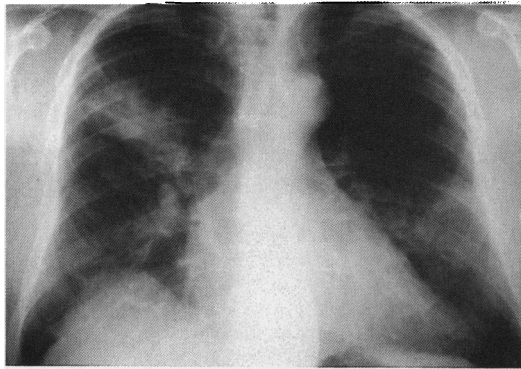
Posteroanterior chest radiograph showing segmental collapse within the right upper lobe with infiltration in the left upper lobe.
